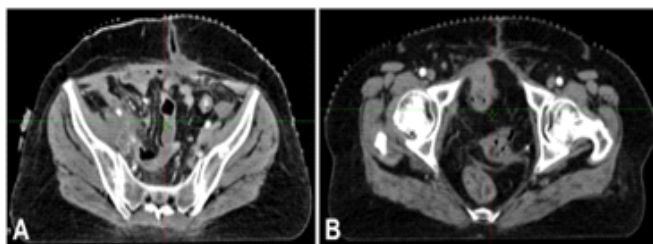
CT Images Showing Pelvic Mass Involving the Bladder near Uterine Wall
